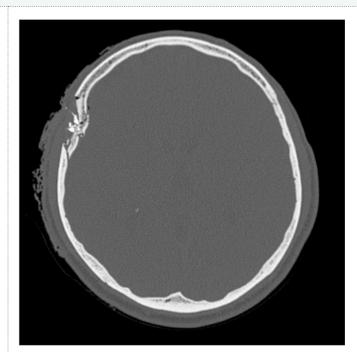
Axial CT Bone window demonstrating a right frontal depressed skull fracture.
